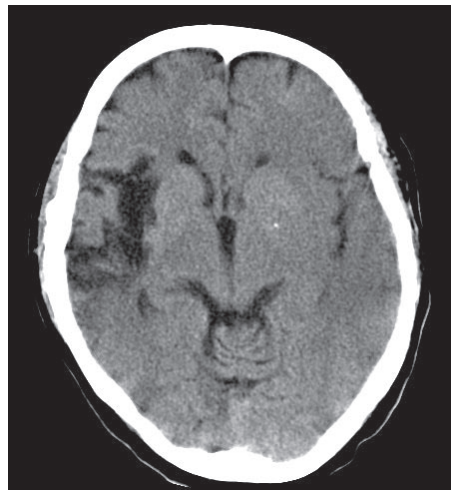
Non-contrast axial CT brain.
